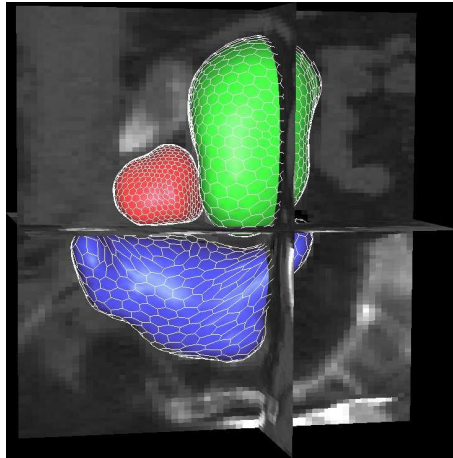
Lower abdomen structures segmentation. The prostate (red), the bladder (green) and the rectum (blue) in a CT image.*
